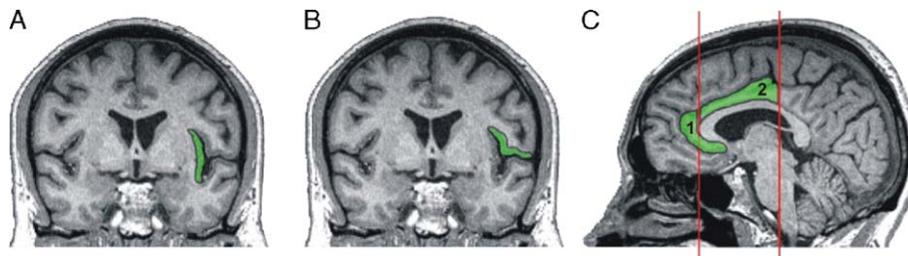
Example for placement of regions of interest (ROIs) in individual MRI scans (marked with green lines). (A) ROIs for the insula were separated into an anterior and a posterior part at the vertical plane through the anterior commissure ($y = 0$). The location of the frontal slices (coronal) was on average 10.1 ± 2.1 mm anterior, the location of the posterior slices 6.2 ± 2.1 mm behind the anterior commissure (in coronal plane). Insular and opercular ROIs were measured on the same coronal slices (anterior and posterior) as demonstrated in examples A and B. (B) ROIs in the opercular cortex were placed in its inner vertical part, facing the insula, down to the “lip” facing the temporal lobe. Frontal (anterior) and parietal (posterior) operculum are separated by the central sulcus, which at this level is also located approximately at $y = 0$. (C) Two ROIs were chosen within the cingulate cortex. The anterior cingulate (ACC, green area 1) included the rostral perigenual part up to the tangent at the anterior part of the corpus callosum (left vertical line), the midcingulate (MCC, green area 2) included the adjacent part ending at the coronal plane through the posterior commissure (right vertical line).
